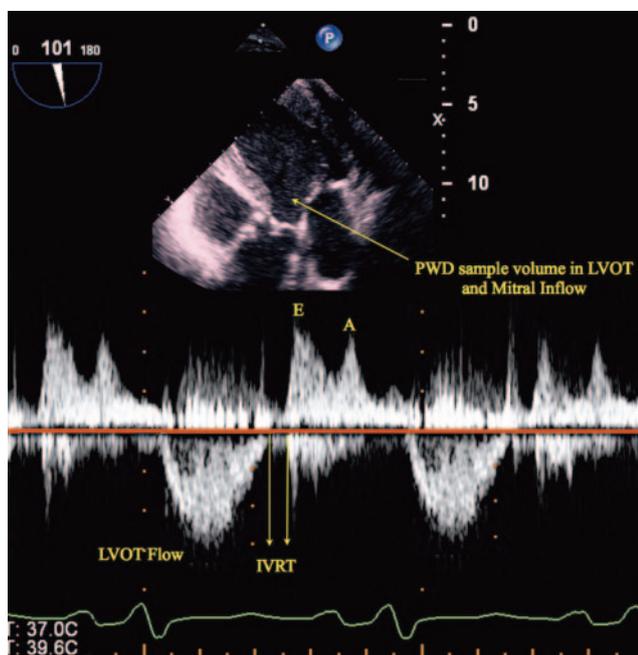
Measurement of isovolumetric relaxation time (IVRT). The transesophageal echocardiography probe is advanced to the deep transgastric position, and with omniplane rotation and probe manipulation, a parallel Doppler alignment is achieved and a sample volume of pulse wave Doppler (PWD) is placed between the left ventricular outflow tract (LVOT) and mitral inflow to obtain a spectral display that simultaneously displays the left ventricular outflow and mitral inflow profile. IVRT is measured as the time interval between the LVOT velocity time integral to the start of the transmitral flow. AV = aortic valve; MV = mitral valve.
